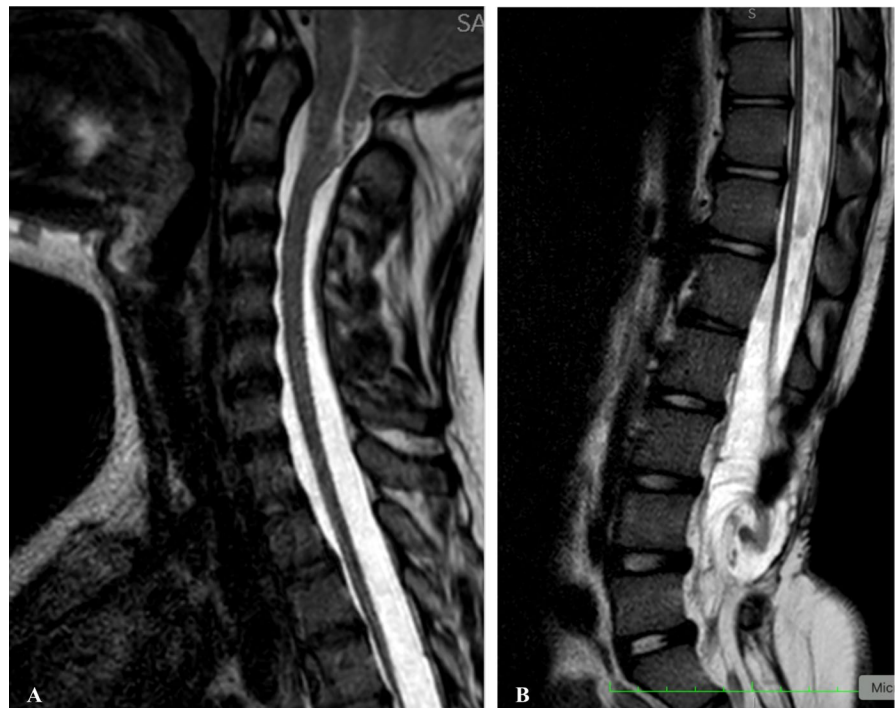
(A) Sagittal T2-weighted image showing spinal cord atrophy below the cervicothoracic junction without syringomyelia; (B) Lumbar and sacral sagittal image demonstrating extensive posterior spinal dysraphism from L2 to L5 with dural ectasia extending into subcutaneous tissues without cutaneous communication.
